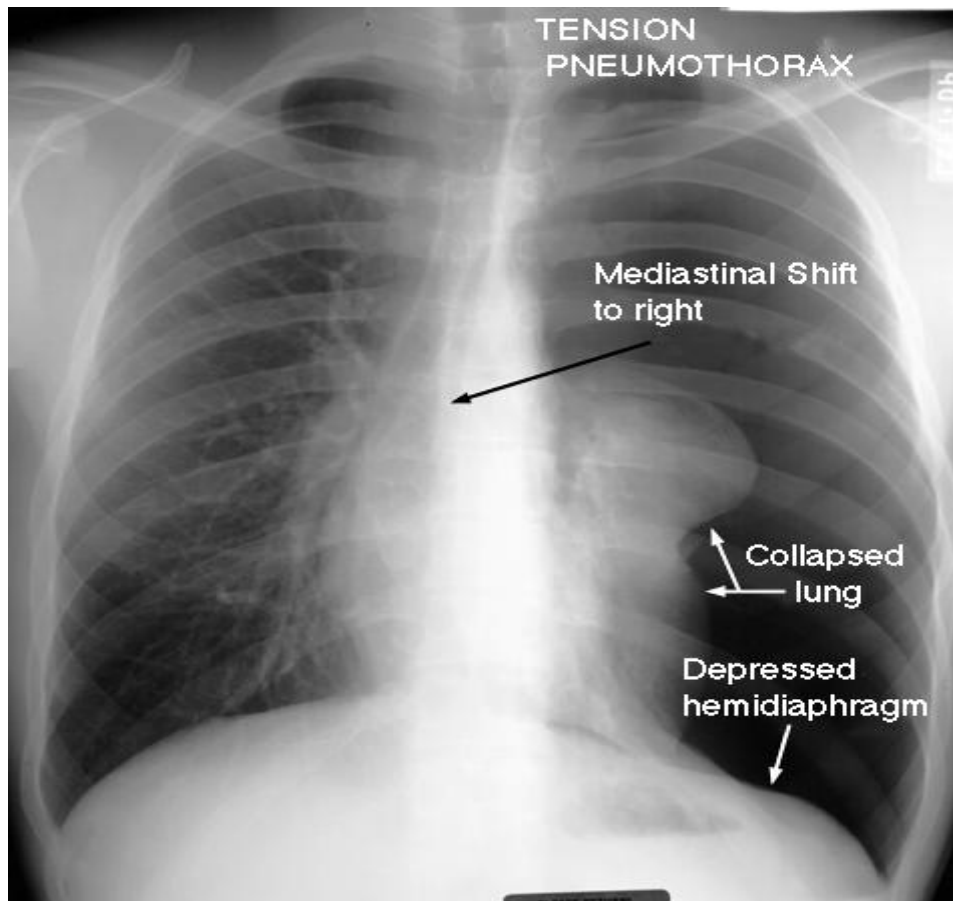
Chest x-ray (PA view) showing tension pneumothorax
